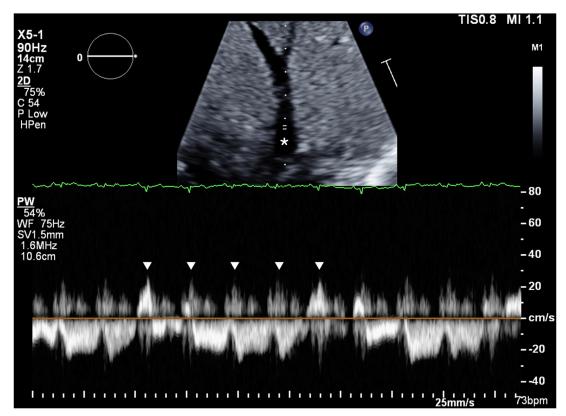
Subcostal view on TTE of the hepatic vein insertion (*) into the IVC using pulsed-wave Doppler shows evidence of venous flow reversal (*arrows*).
